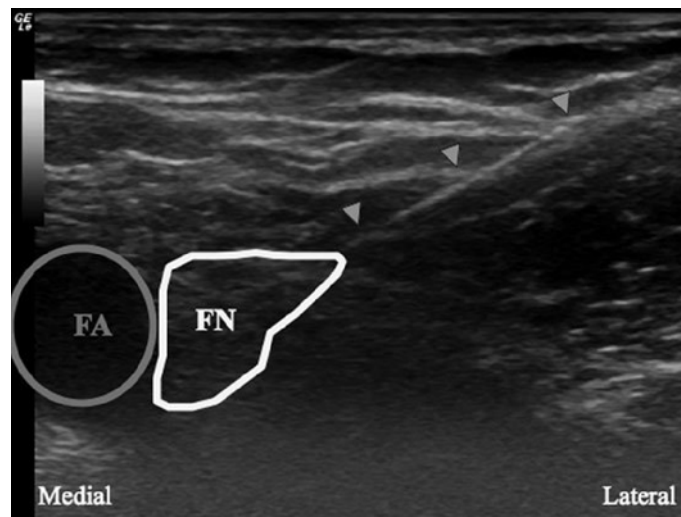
Ultrasound-guided femoral nerve block.
